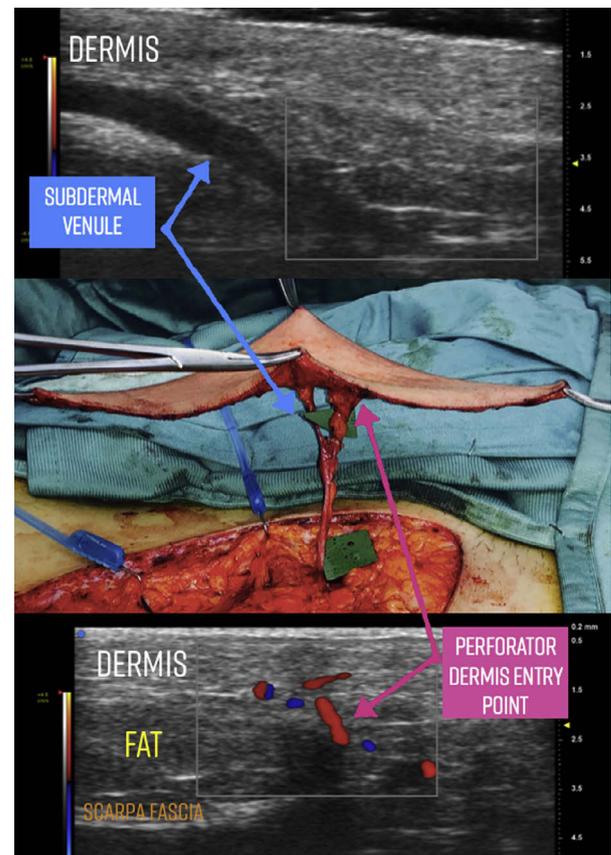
(Above) Subdermal venule with small venule branches directly piercing the dermis and converging into SCIP comitantes venule has been identified using 70 Mhz linear probe. (Center) Intraoperative picture of Superficial Circumflex Iliac Artery Pure Skin Perforator flap harvest based on the perforator dermis entry point and a subdermal venule connecting with the SCIP comitantes vein. (Below) Preoperative planning using ultra-high frequency ultrasound showing the high fidelity findings with the intraoperative ones. Notice the scale on the right side in mm.
